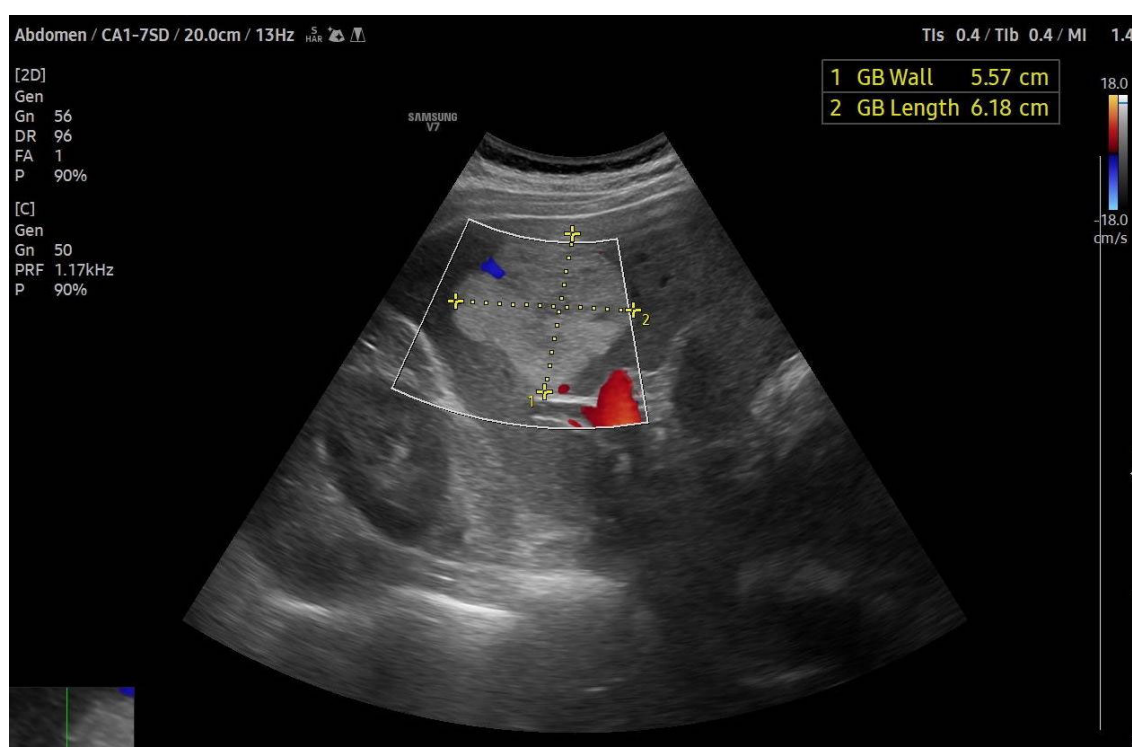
Slightly heterogeneous hyperechoic lesion with absence of flow on color Doppler, characteristic of a large hepatic hemangioma.
